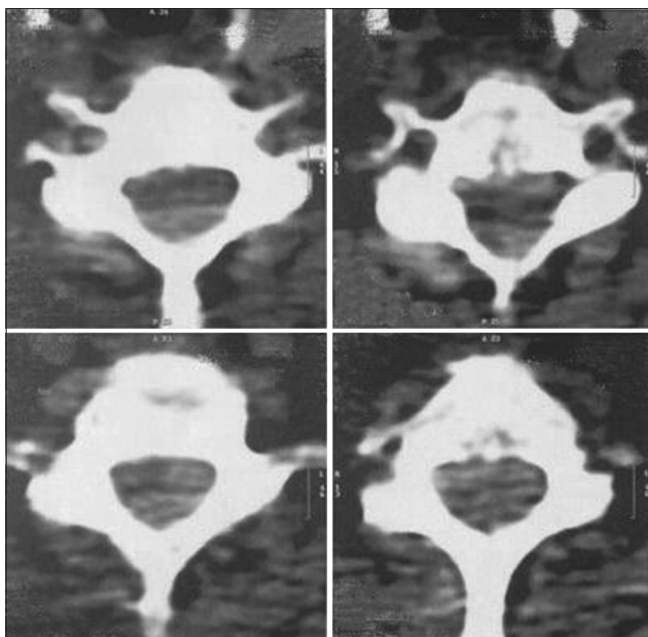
Axial computed tomography scan of cervical spine showing hyperdensity in epidural space
